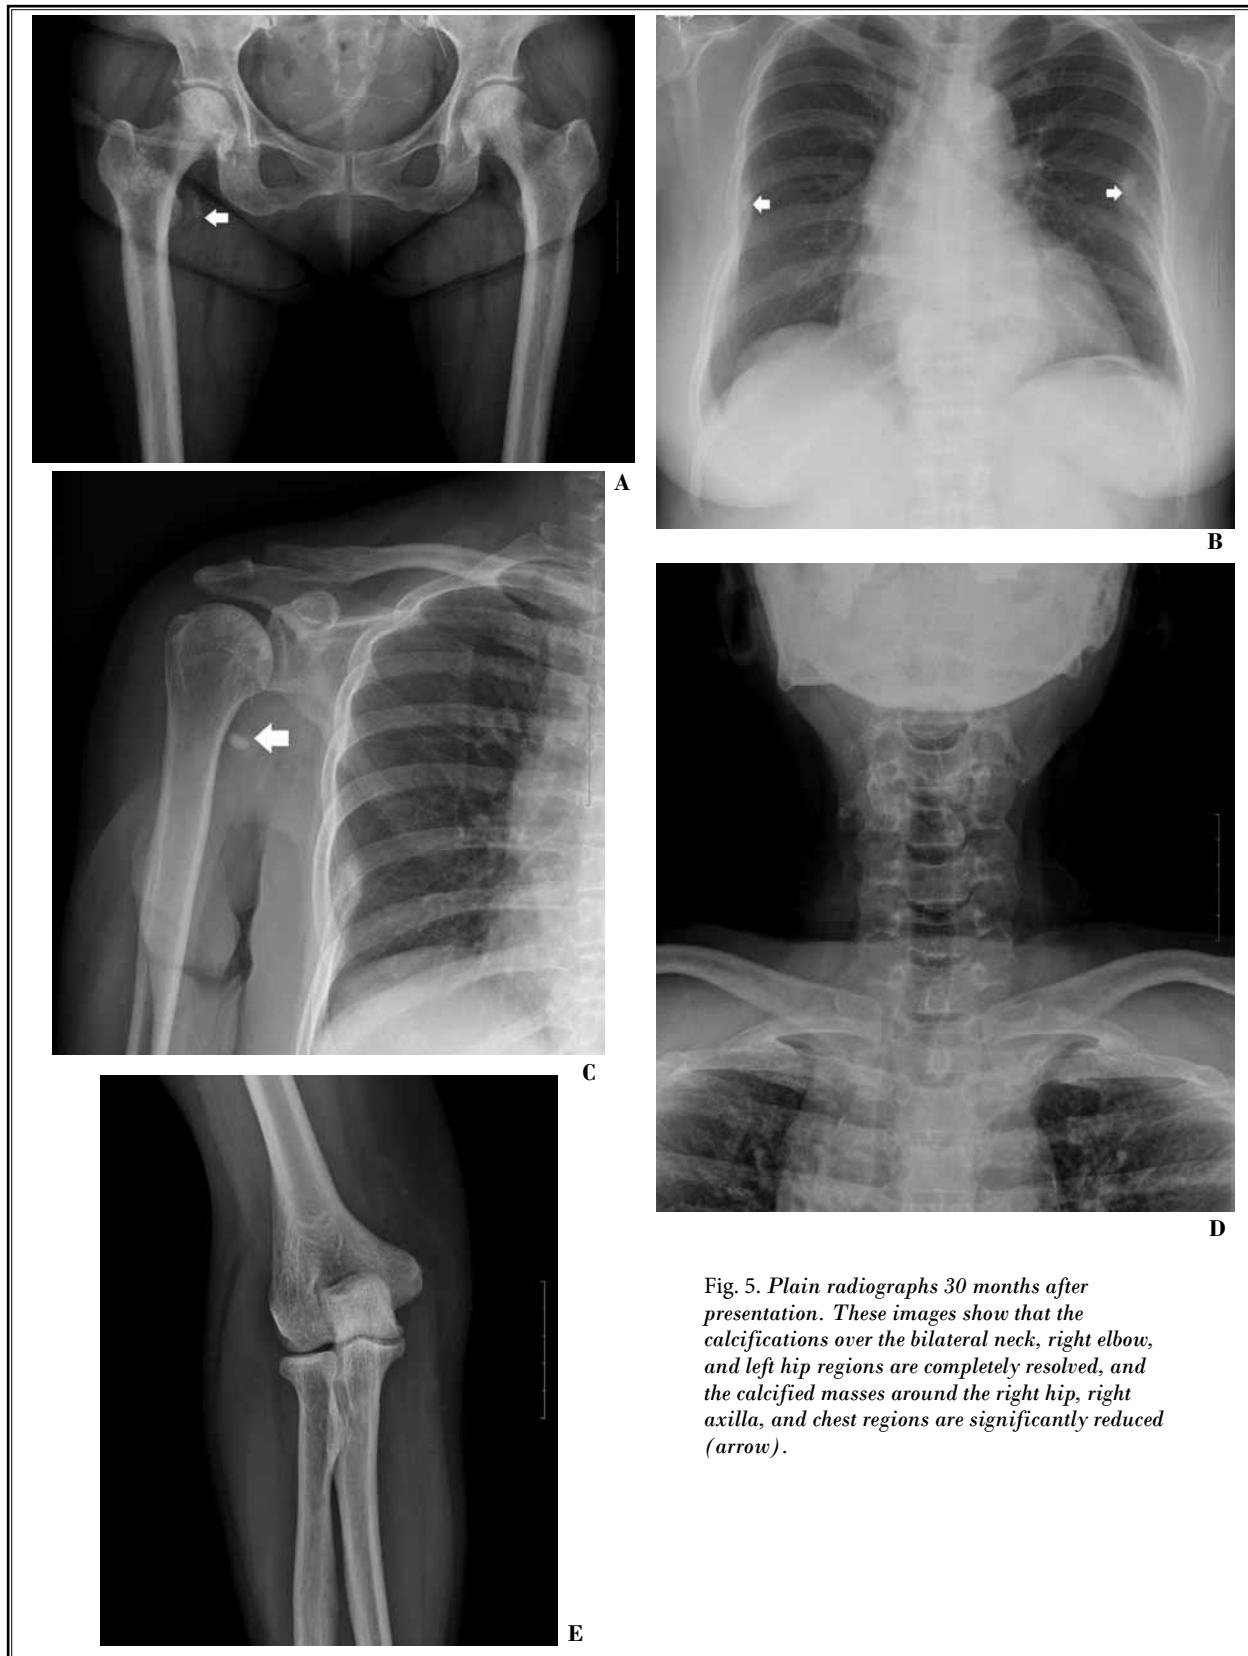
Plain radiographs 30 months after presentation. These images show that the calcifications over the bilateral neck, right elbow, and left hip regions are completely resolved, and the calcified masses around the right hip, right axilla, and chest regions are significantly reduced (arrow).
